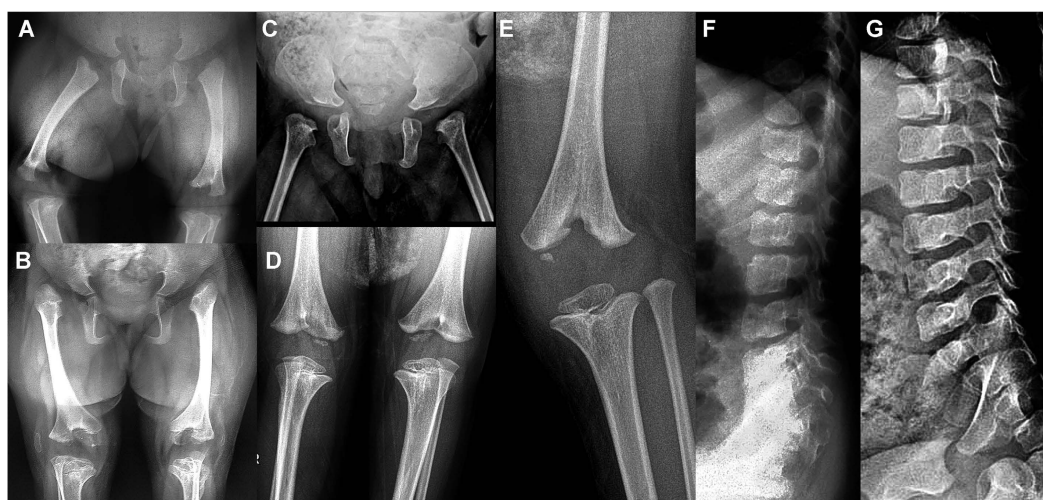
Skeletal-radiographic features. Panels A and B: patient 2 at birth (A) and at age 5 years (B) showing underossified pubic bones; bilateral dysplasia of the femoral heads at birth resulting in hip dislocation at age 5 yrs; and a “bifid” appearance of the distal femur with epiphyseal delay at birth, with dysplastic epiphyses that are “socketed” in the bifid femur at age 5 yrs; and small, laterally dislocated patellae. Panels C, D and E: Patient 1 at birth (C) with dysplastic femoral heads and at age 4 years (D,E) showing the bifid distal femur and the markedly dysplastic distal femoral epiphyses. The proximal tibial epiphyses are too small but less severely affected. Panels F and G: lateral lumbar spine of patient 3 at age 3 yrs (F) and of patient 1 at age 4 yrs (G) showing remnants of coronal clefts of the vertebral bodies. The clefts are prominent at birth and gradually disappear as ossification progresses.
